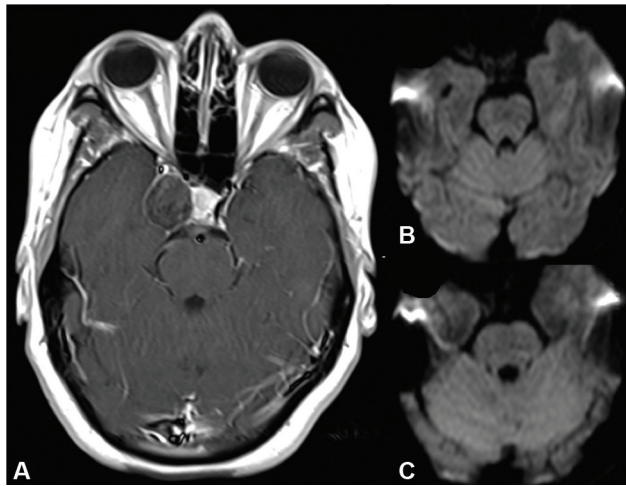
(A) Preoperative axial T1 gadolinium-enhanced magnetic resonance imaging showing the right cavernous sinus epidermoid cyst. (B, C) Two different axial views on postoperative diffusion weighted imaging without any sign of restricted diffusion, meaning no signs of tumor residual.
